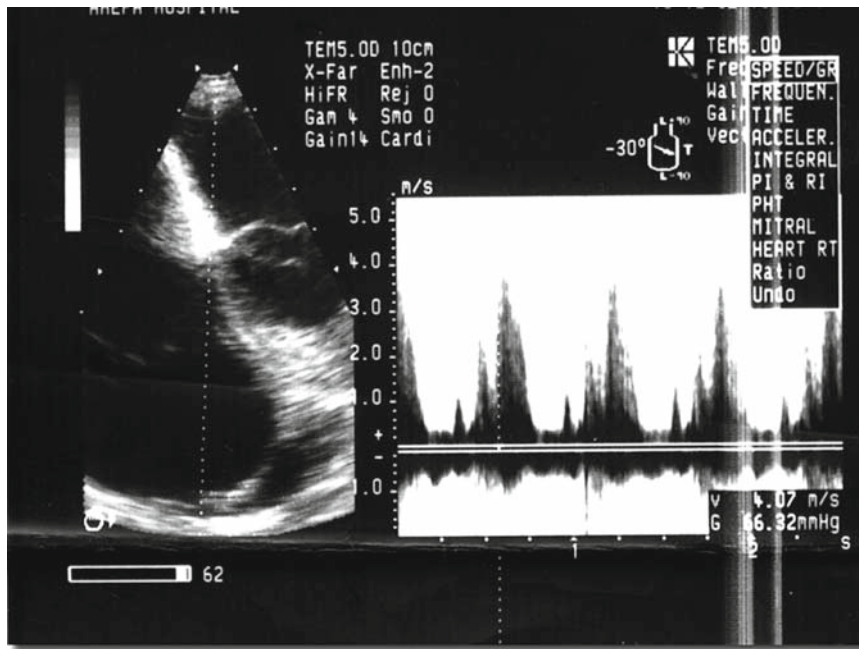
Transesophageal echocardiography (TEE) findings: four-chamber view with small left ventricular cavity size, enormous enlargement of the right ventricle (RV) and right atrium (RA), and interventricular septum (IVS) flattening. Continuous-wave Doppler with tricuspid valve regurgitation, pressure gradient (PG), 66 mmHg
